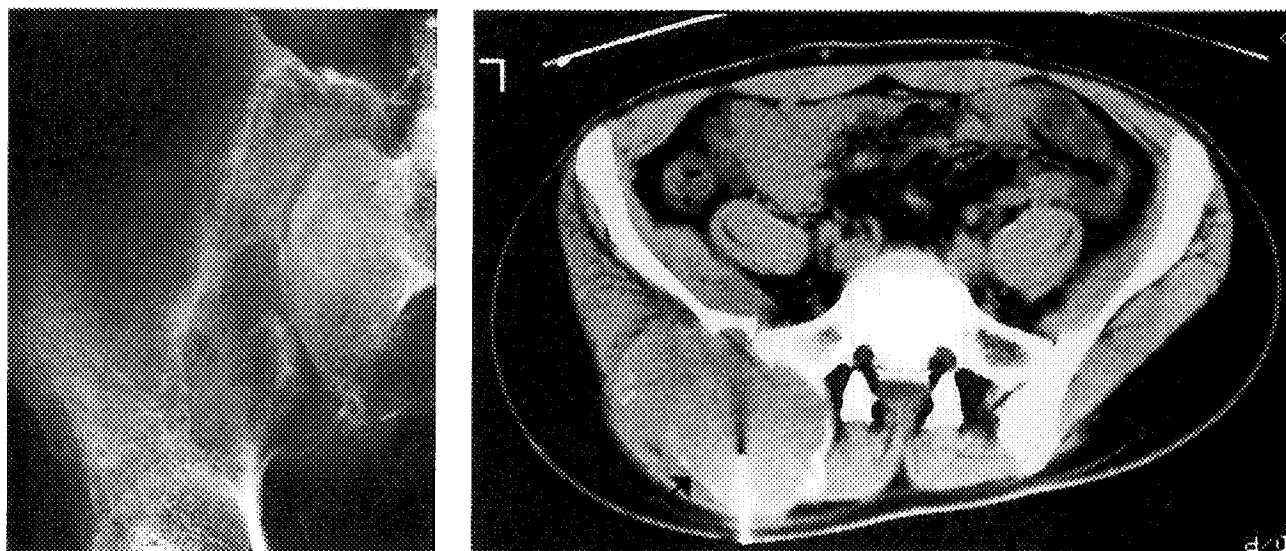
Left, AP radiograph of a portion of the pelvis of a patient with a giant cell tumor in the pelvis shows a destructive tumor near the sacroiliac joint. Right, CT scan of the pelvis shows a large extrapelvic soft-tissue mass (arrow) that proved to be a giant cell tumor.
